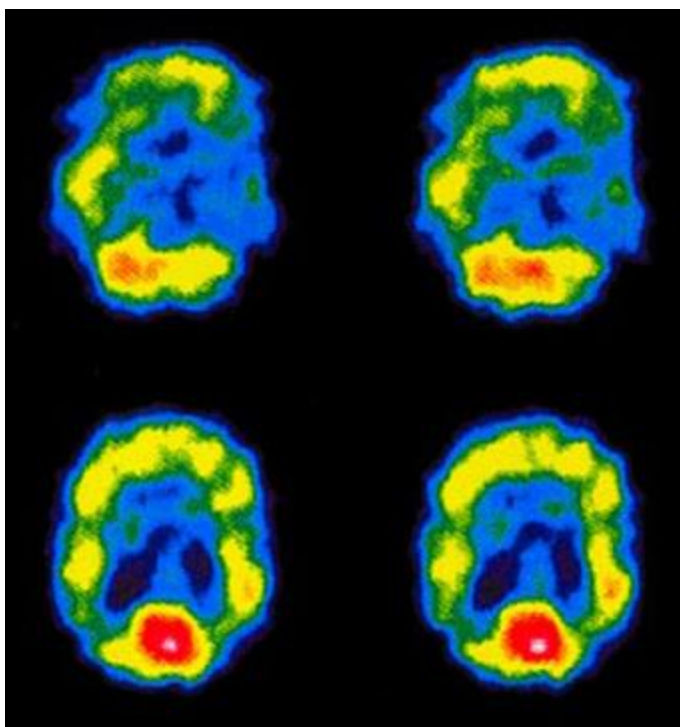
A SPECT scan of a patient with uncontrolled complex partial seizures. The temporal lobe on the left side of the brain shows less blood flow than the right, confirming for the surgeon the nonfunctioning area of the brain causing seizures.
